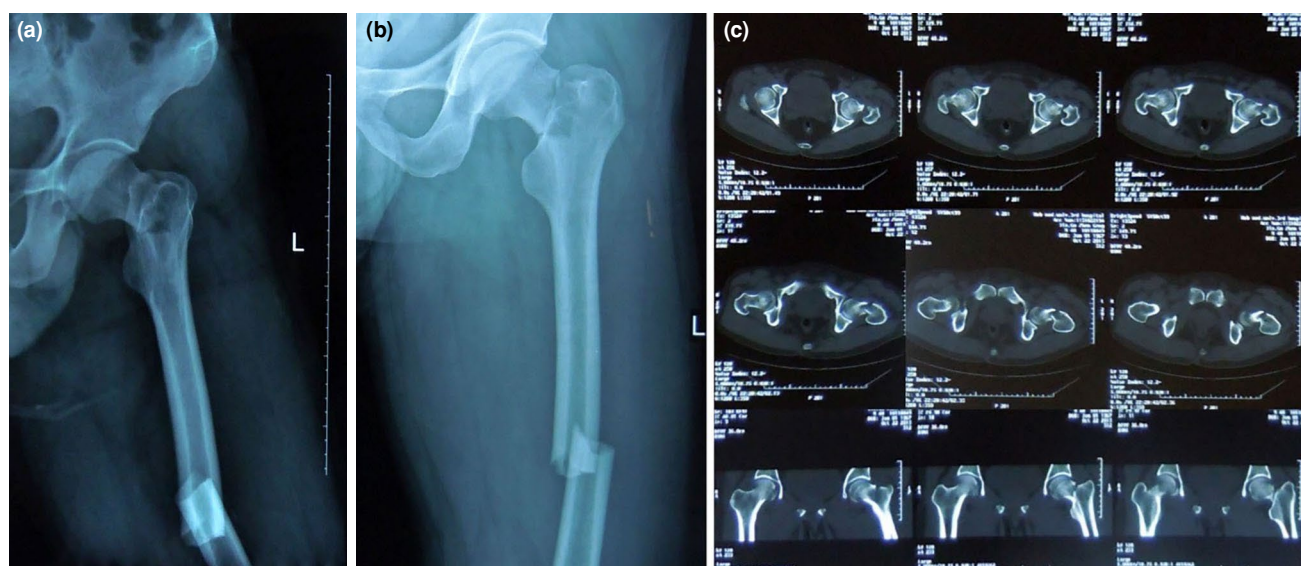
The patient is a 35-year-old male who suffered from left femoral neck and shaft fracture in a traffic accident. (a) Anterior and posterior images of X-ray image of fracture. (b) Lateral image of X-ray image of fracture. (c) Computed tomography image of femoral neck fracture.
